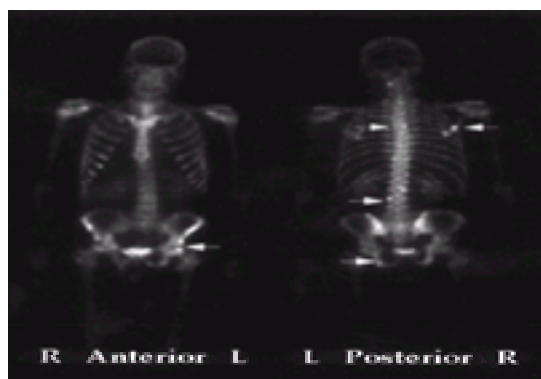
Somatostatin-receptor scintigraphy in a patient who developed locally recurrent gastrinoma in lymph nodes; the study was done to exclude distant disease. The scintigram demonstrated numerous bony metastases (arrows), which precluded repeat surgery; the patient was treated with chemotherapy.
